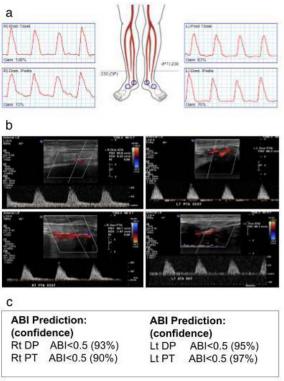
Patient with diabetes mellitus and bilateral toe amputations, a) continuous doppler waveforms of non-compressible arteries and b) doppler ultrasound waveforms. c) Model ABI predictions
